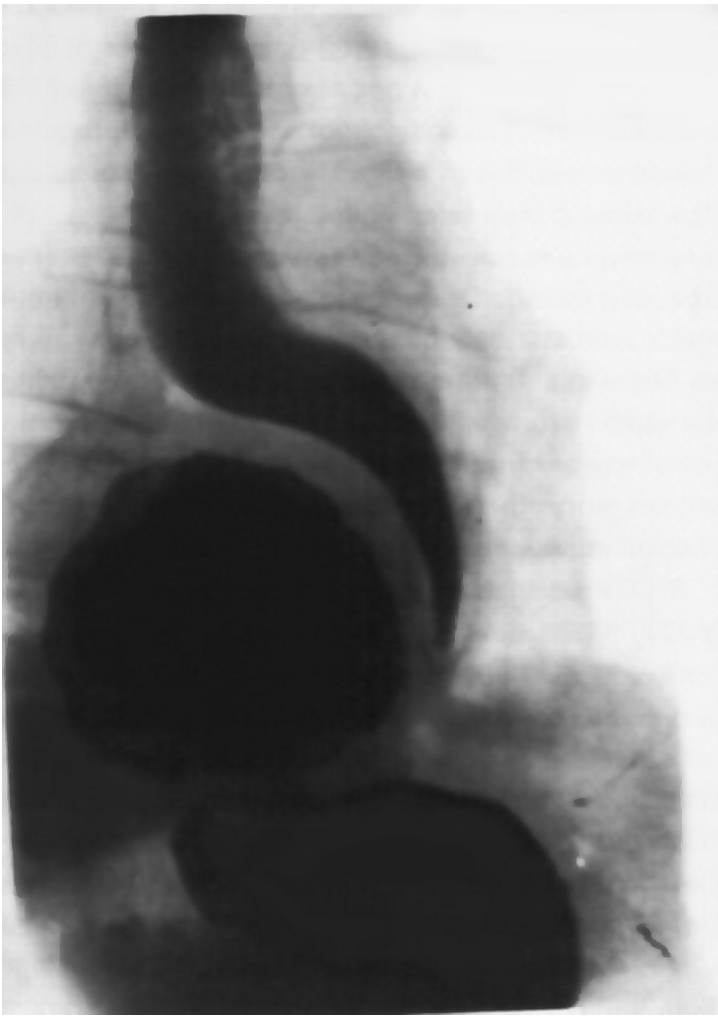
Roentgenogram. Paraesophageal HH (according to Ya. G. Kolkin et al., 1996 [8]).
